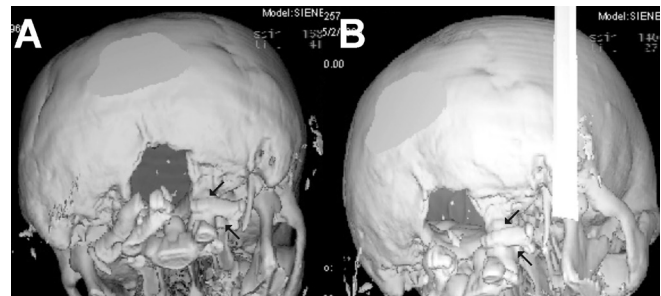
Spiral CT after the tumor removal; the zone of osseous resections is visualized. (a) CT plane at C1 level, (b) CT plane at C2 level
